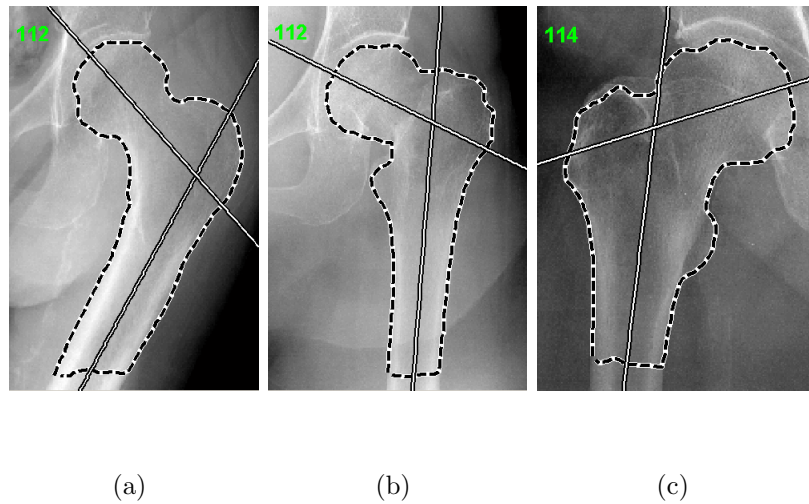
The x-rays of (a),(b) and (c) were not taken in the expected posture hence causing the classifier to fail.
